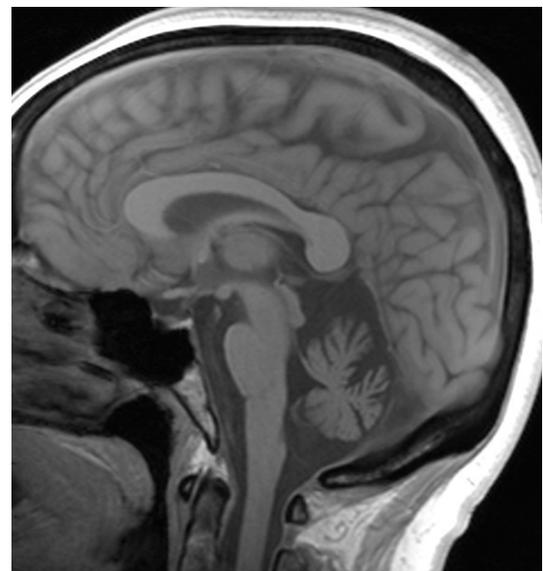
MRI scan without contrast showing severe cerebellar atrophy in a 61 year old woman with neurological history of OPCA by three years. In addition, this patient has atherosclerosis at the basilar artery and V4 segments of the vertebral arteries.
